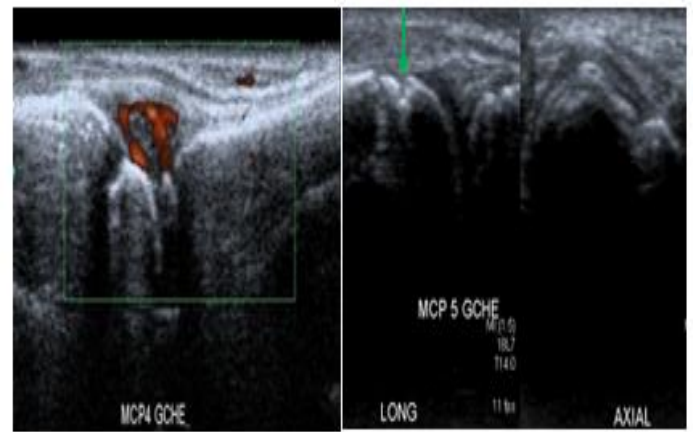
Power Doppler synovitis positive MCP 4 left ; bone erosion MCP 5 left , dorsal longitudinal and axial cuts .
